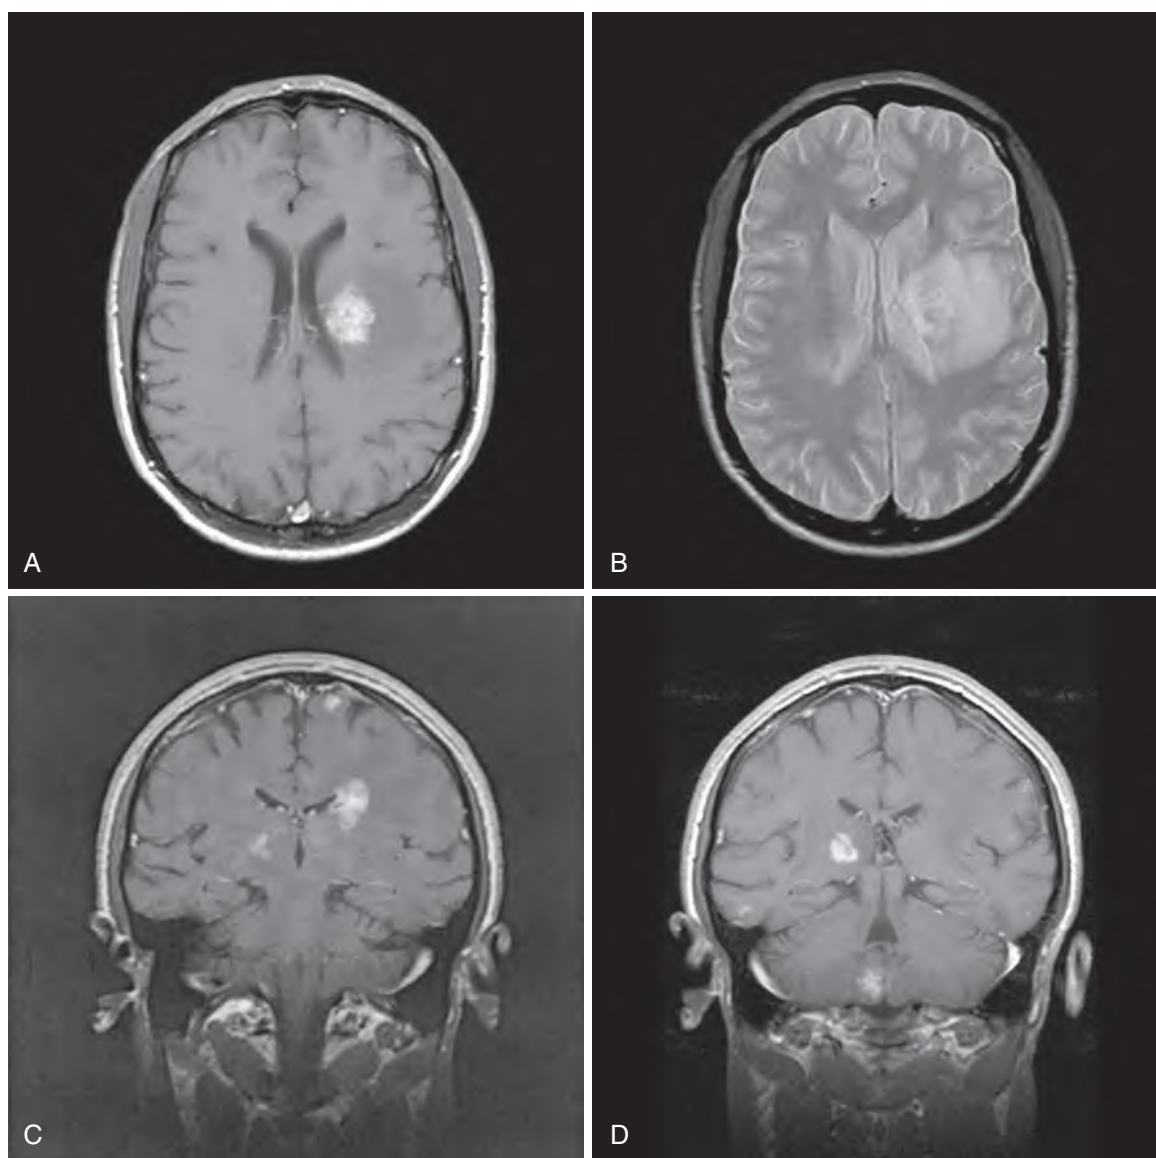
Brain magnetic resonance images of a 38-year-old man with acquired immunodeficiency syndrome and *Toxoplasma* encephalitis. The T1-weighted image after gadolinium injection shows a large enhancing lesion in the left frontal lobe (A), surrounded by edema, as demonstrated on the T2-weighted image (B). Additional smaller enhancing lesions can be seen on coronal cuts in the right thalamus and at the left convexity (C) and in the right cerebellum and right temporal lobe (D).
